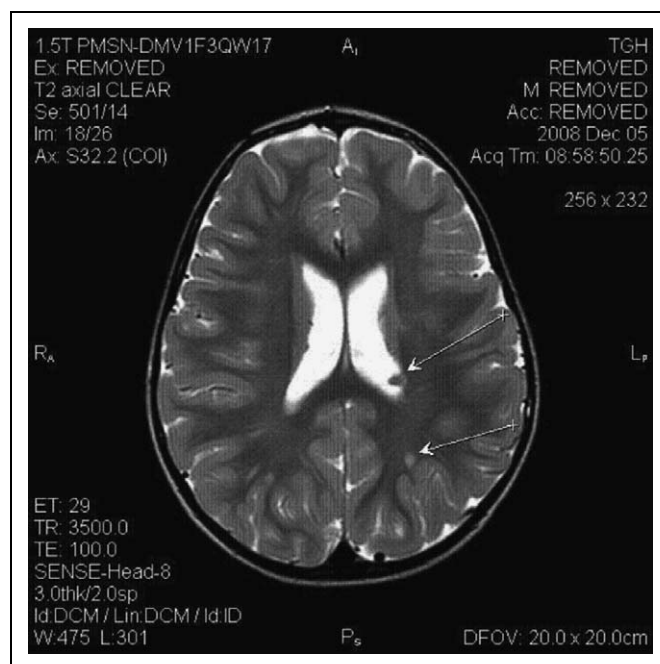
Magnetic resonance imaging (MRI) of the brain, T2 axial image. Subependymal nodule attached to the right lateral ventricle and 1 in the subcortical region on the right (arrows).
